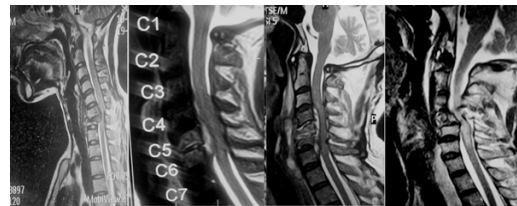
Preoperative T2 sag. MRI of the patients having C6C7, C5C6 and C3C4 Potts involvement.
